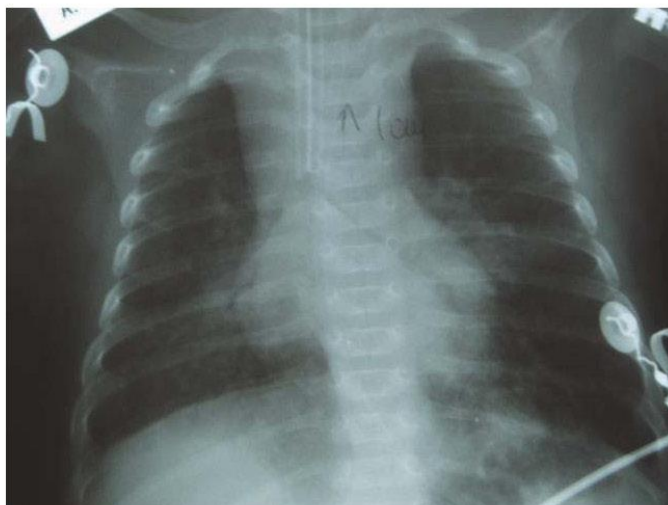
Chest radiograph. There is an endotracheal tube in situ. Both bronchus intermedius and left main bronchus are markedly narrowed. The parenchyma is difficult to evaluate but even so, the left cardiac margin is obscured by lingular air-space disease.
